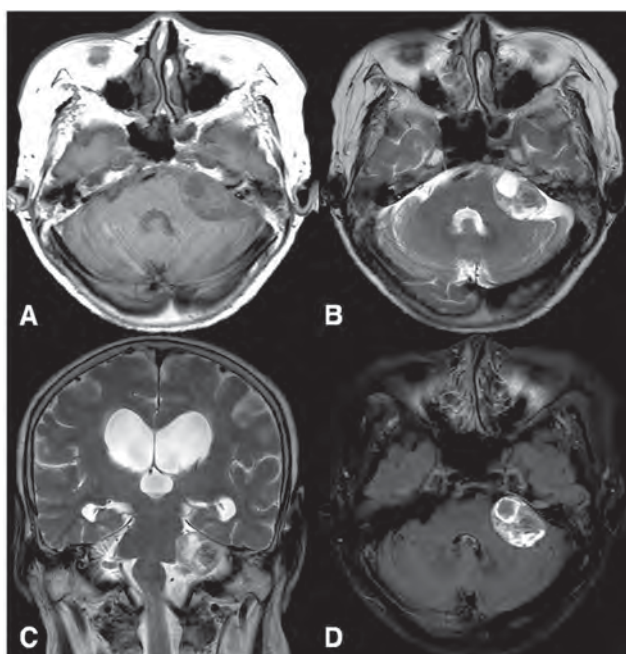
Brain MRI revealed 28 × 18 × 22 mm sized vestibular schwannoma with cystic change and heterogeneous enhancement (intratumoral hemorrhage) in left cerebellopontine cistern with intracanalicular extension when the patient came to emergency room with severe headache. (A: T1 weighted axial, B: T2 weighted axial, C: T2 weighted coronal, D: Fat-suppressed, T1 weighted axial)
